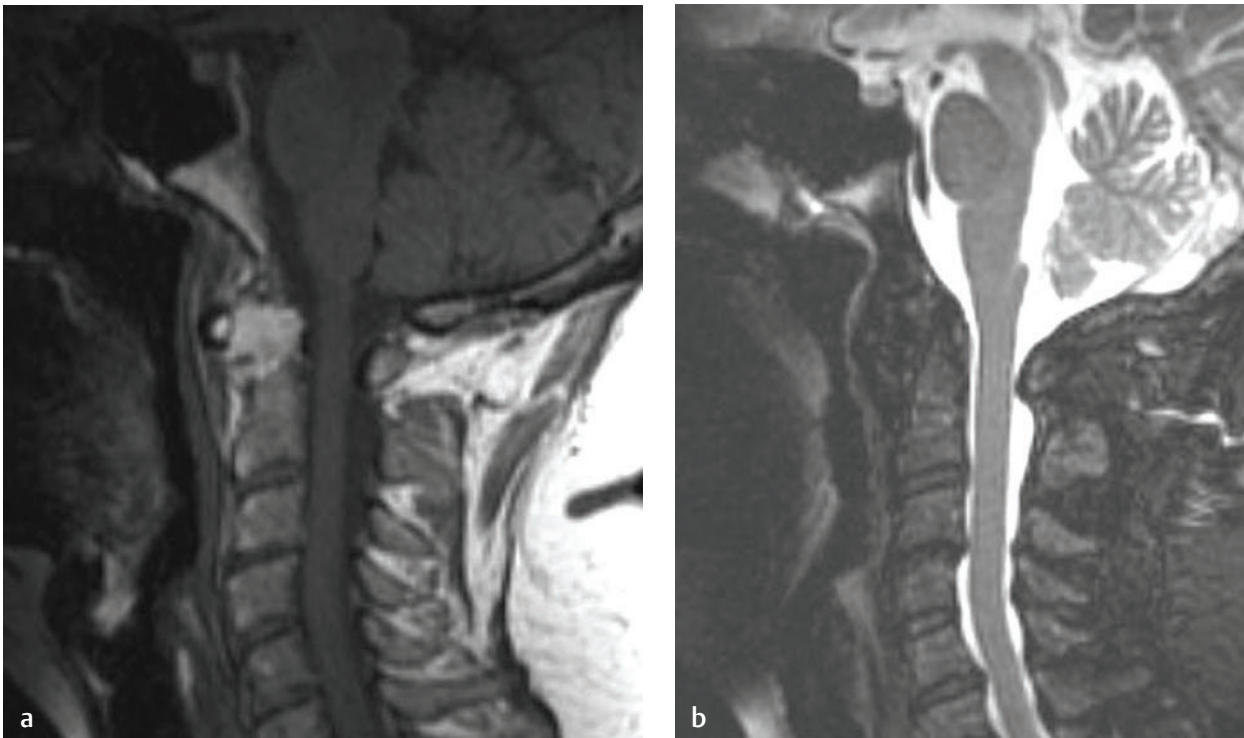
These sagittal (a) T1-weighted and (b) STIR images of another patient with RA and large pannus formation that, in this case, the pannus has caused substantial osseous erosion.
